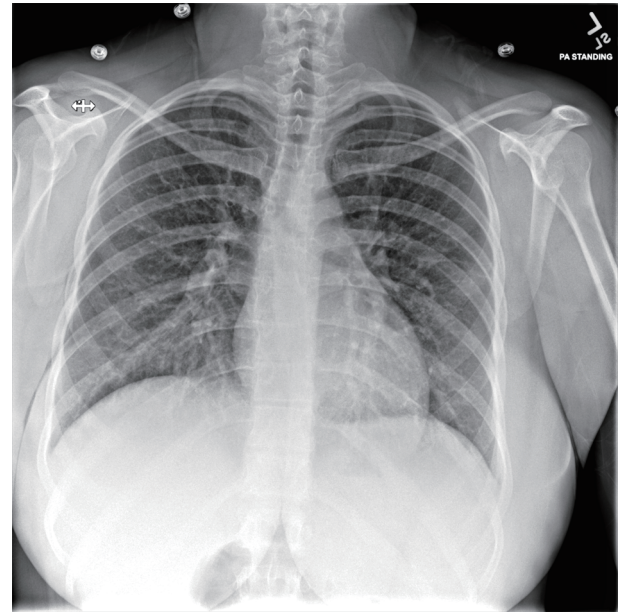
Posteroanterior (PA) standard chest X-ray from second emergency department visit 2 days later.
